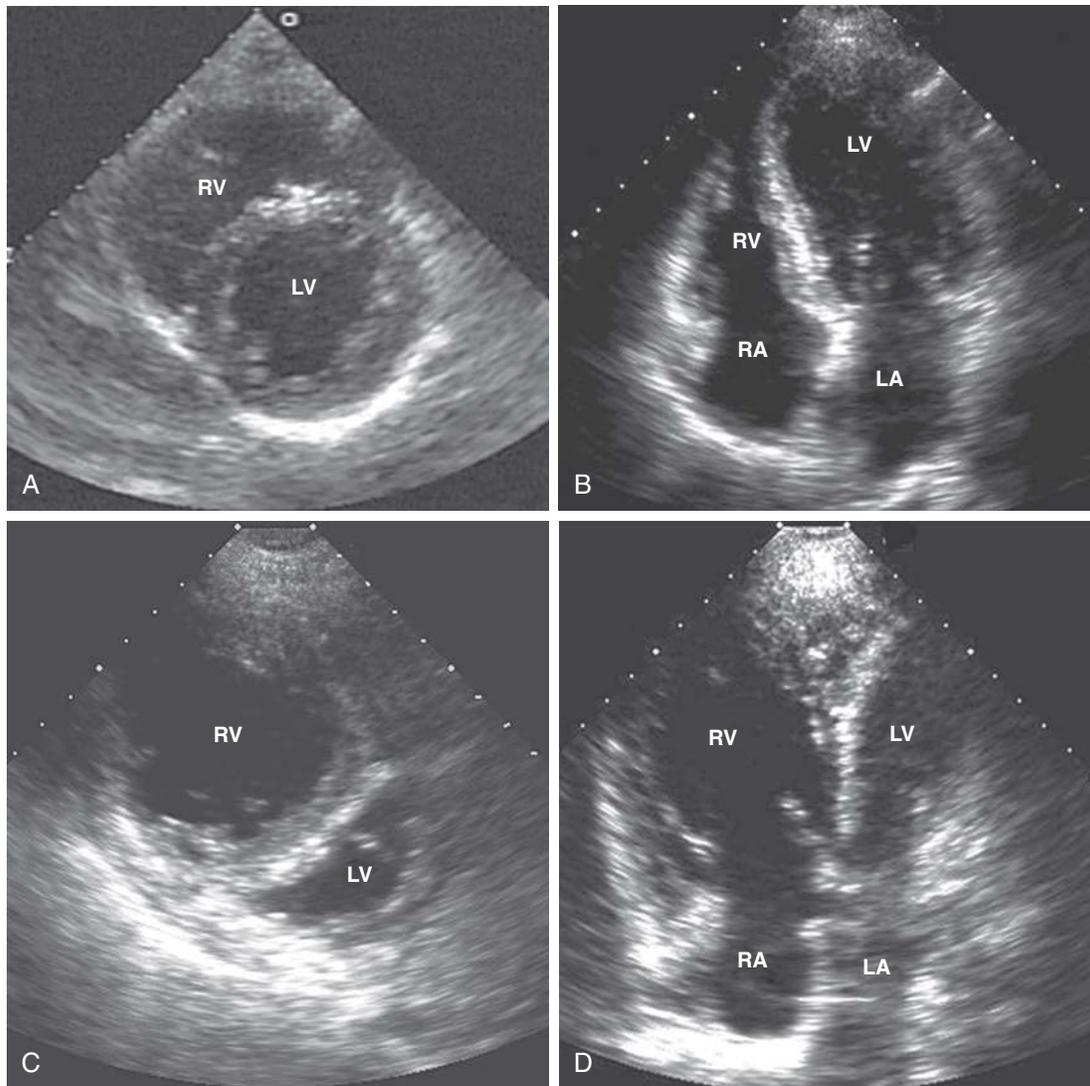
Severe right ventricular failure and dilation. A, Normal transthoracic parasternal short-axis view of the left ventricle (LV) and right ventricle (RV) at the midpapillary muscle level. B, Normal transthoracic apical four-chamber view of the LV and RV. These pictures of a normal heart depict the relationship between the LV and RV, with the LV being normally larger than the RV and the interventricular septum bulging slightly toward the RV. C, Transthoracic parasternal short-axis view of the LV and RV in a patient with severe right ventricular failure and dilation. The right ventricular cavity is seen to be much larger than the left ventricular cavity. Because of the high volume and pressure in the RV, the interventricular septum is bulging toward the left. This gives the LV a characteristic “D” appearance. D, Transthoracic apical four-chamber view of the same patient shows the inverse relationship between the left ventricular and right ventricular sizes. The right ventricular dilation can occur only if associated with a proportional reduction in LV diastolic dimension (“ventricular interaction”). This reduction in left ventricular diastolic dimension significantly impairs left ventricular relaxation and changes the pressure-volume relationship of the left heart chambers. LA, Left atrium; RA, right atrium.
